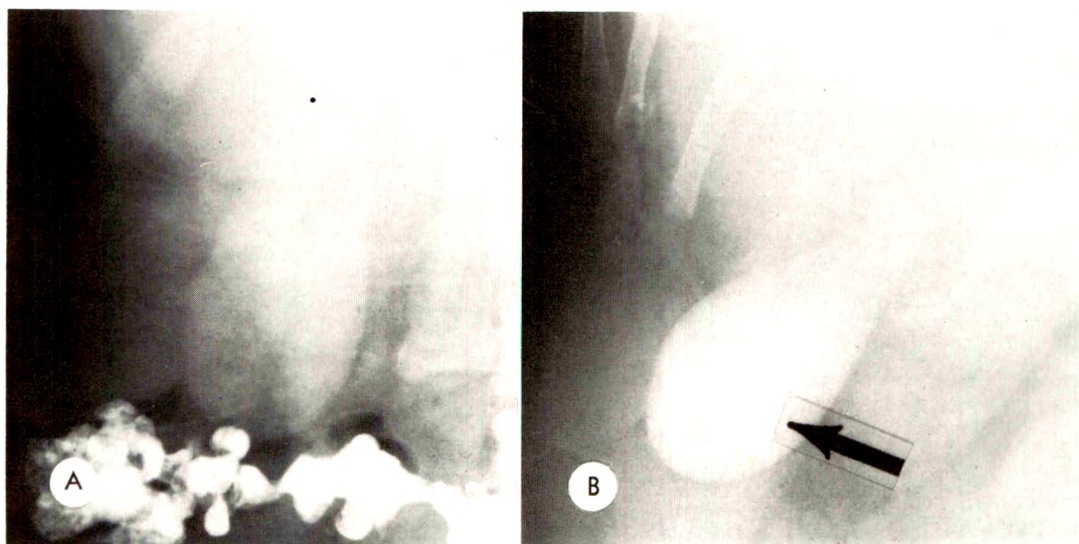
Example of provincialism. (A) The gallbladder was considered normal. The radiologist did not call for roentgenograms made 3 years previously (B) on which gallstones were evident. The continued presence of stones was later confirmed.
